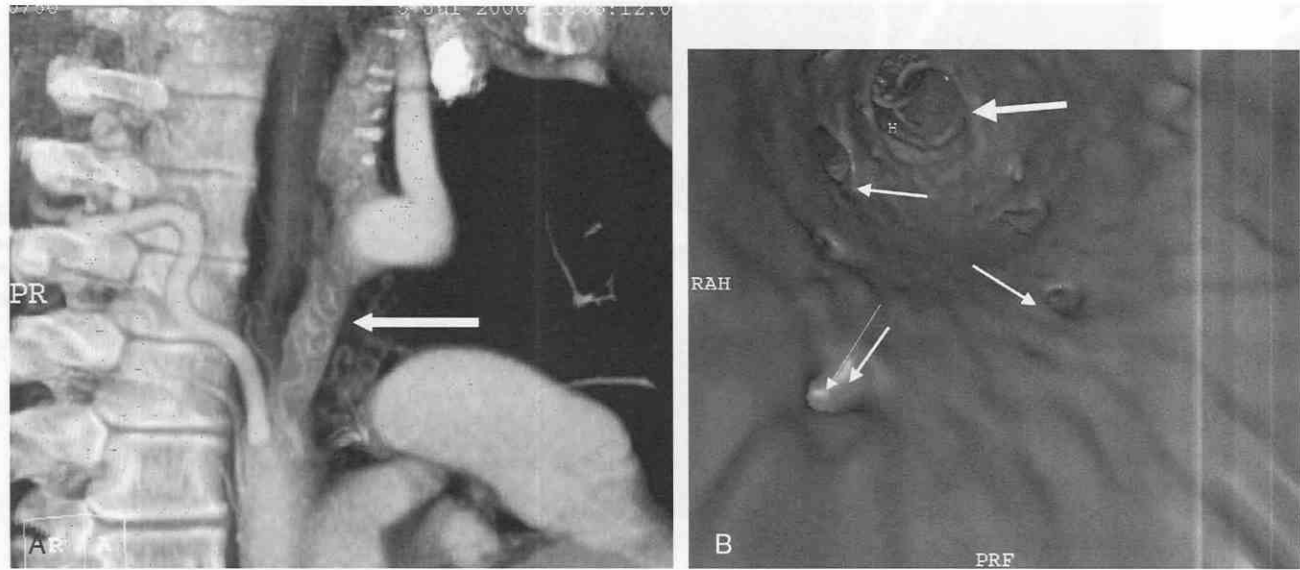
A, Sagittal oblique volume-rendered CT scan shows persistent coarctation (arrow) after surgical repair. Note the markedly enlarged third intercostal artery. B, Large arrow shows the coarctation. Small white arrows show prominent intercostal artery origins.
